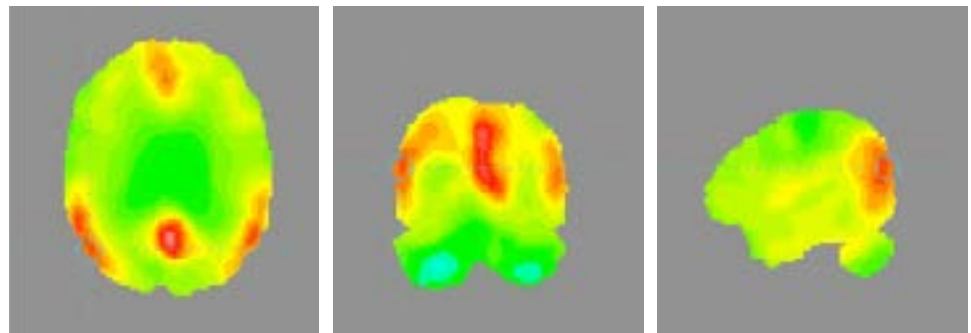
Axial, coronal, and sagittal slices showing SUVR values through an amyloid PET image; the slices and crosshair position used correlate with those shown in Figure 6. This case shows increased cortical SUVR nearly everywhere; white and grey matter cannot be delineated as in healthy subjects.
